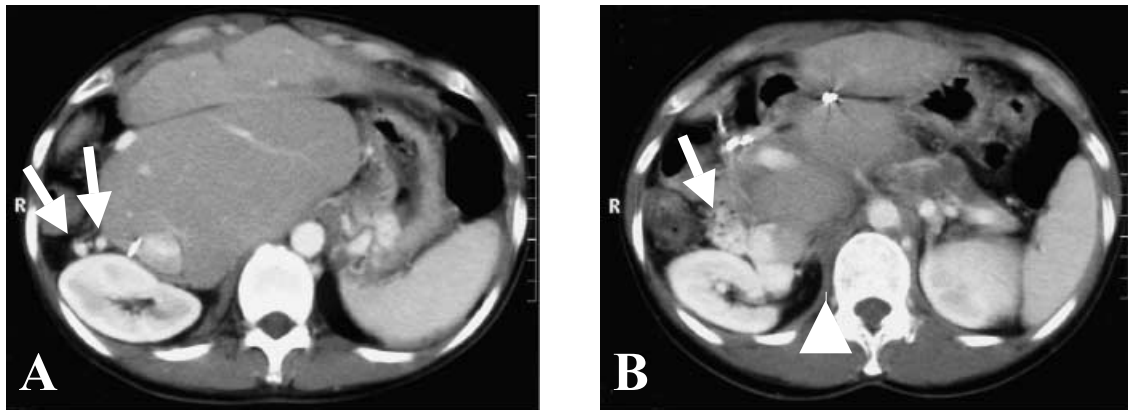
Computed tomography scan of the abdomen reveals markedly hypertrophic remnant liver (the caudate and part of left lobes), a low density area as a postoperative change in the lateral segment, and the inferior vena cava displaced on the right side. Collateral vessels and portosystemic shunt via the duodenal varices are observed (white arrows) (A). Contrast enhanced duodenal varices are located in the lumen of the duodenum (white arrow) (B).
